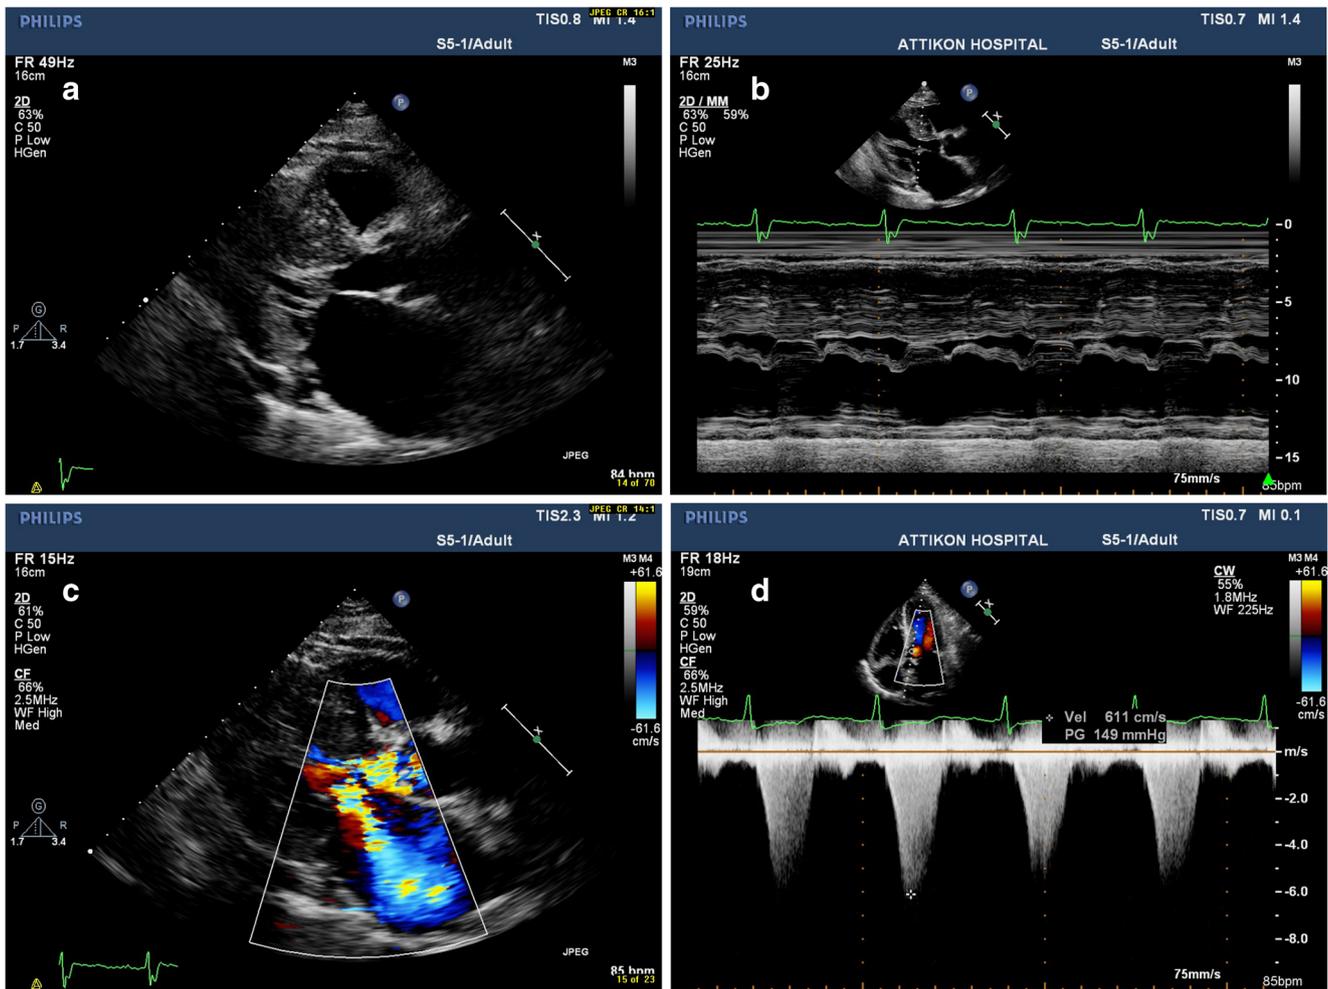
Systolic anterior motion (SAM) of the mitral valve with 2D (a) and m-mode (b) causing LVOT obstruction and SAM-associated MR (c). A maximum instantaneous late peak gradient of 149 mmHg was measured with CW Doppler (d), indicative of severe LVOT obstruction
